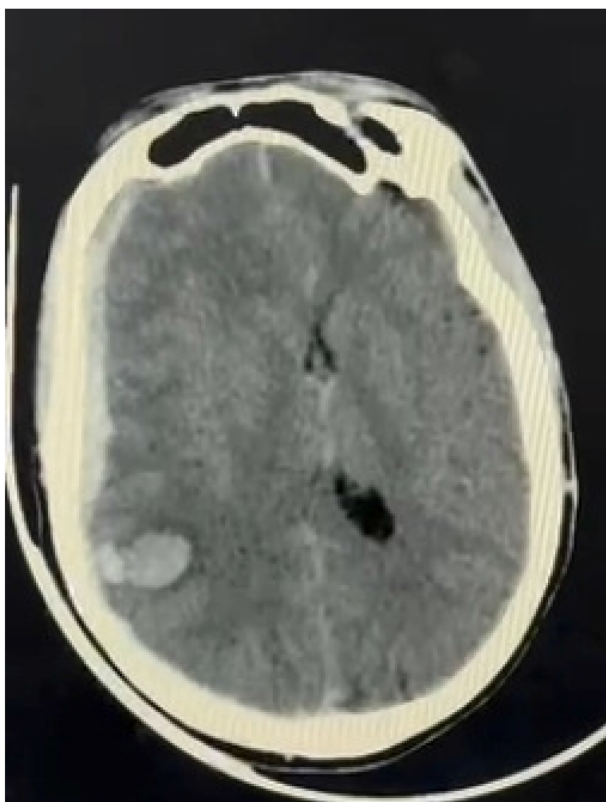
CT scan of the brain showing a right-sided acute subdural hematoma with midline shift and mass effect.
